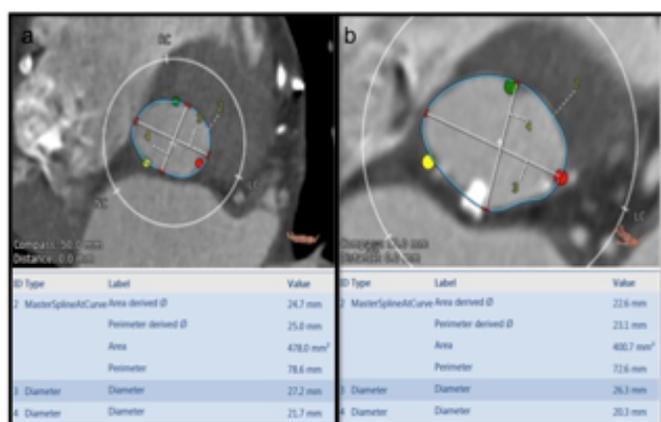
Examples of CT scan morphometric evaluation.
